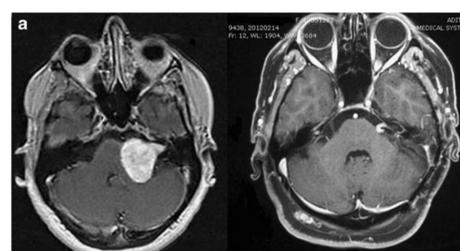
Figure a. Pre- and post-operative MRI images of a large, left-side vestibular schwannoma treated by a presigmoid retrolabyrinthine approach.
